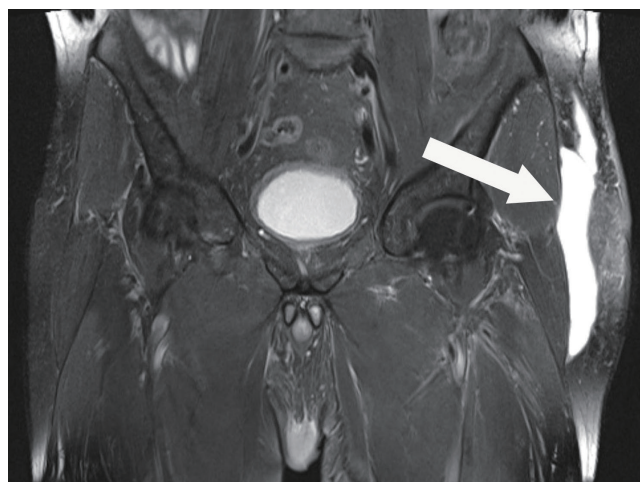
Magnetic resonance imaging. Fluid collection (white arrow) was observed on left thighs.
